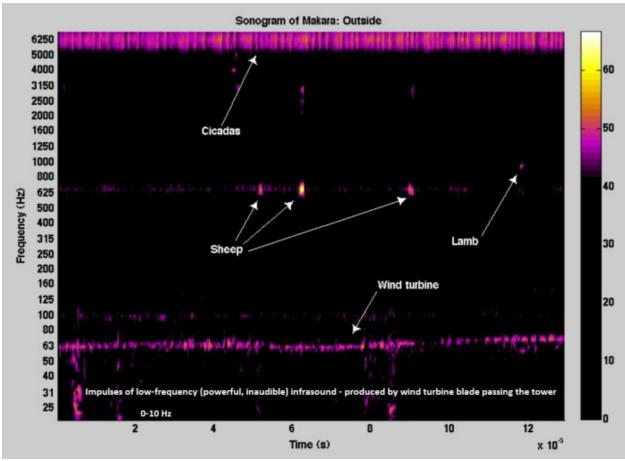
Sonogram, 13 seconds of sound recorded near a wind turbine. The 2014 Tetra Tech noise study told us the 8 Hz found pressure level would be 83 dB at 200 meters. The figure below shows us how much quieter the 8 Hz sound is than the fundamental frequencies (at 1.0 and 1.3 Hz) (Pilger and Cerrana 2016). The figure shows the 5-minute averaged sound measured over three days. 1.0 and 1.3 Hz fundamental frequencies produced by the turbine blades, and harmonics of those vibrations (multiples of the fundamental frequency, like octaves, all produced by the original/fundamental (and louder) 1.0 and 1.3 Hz vibration of air (sound) visible as horizontal stripes. The lower-frequency sound is wind pressure on the sensor. Because these are five-minute averages, the decibel level of the impulses (distinct high-pressure sounds) are much higher decibels than the five-minute average.
